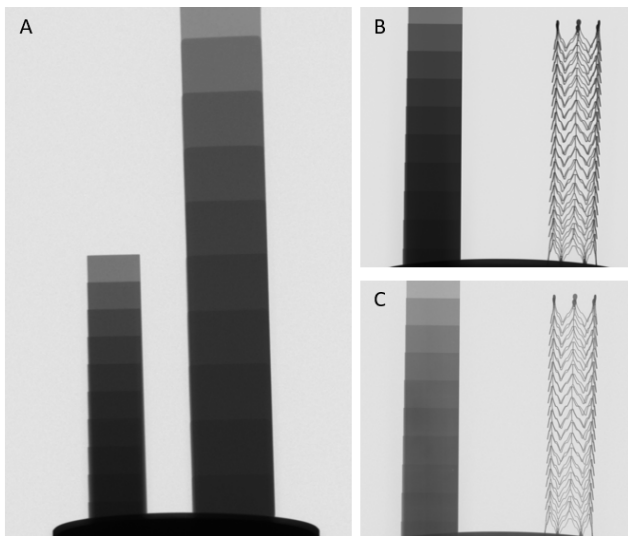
X-ray image of test and reference samples (Fuji FXR Multisuite, 81 kV, 6.16 mAs), Al step wedge 1 – 10 mm, made from 99.5% Al
